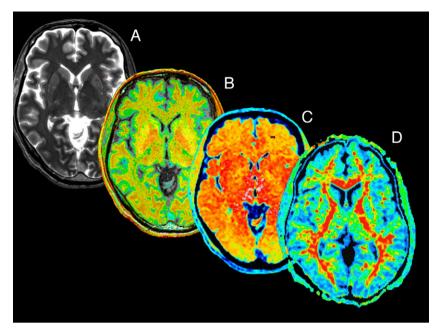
Examples of high quality post mortem MRI in situ. Brain of a 62 years old male scanned 7 h after death. A) Axial T2-weighted image. B) Corresponding relaxometry map. C) Corresponding magnetization transfer ratio MTR map. D) Corresponding fractional anisotropy map.
